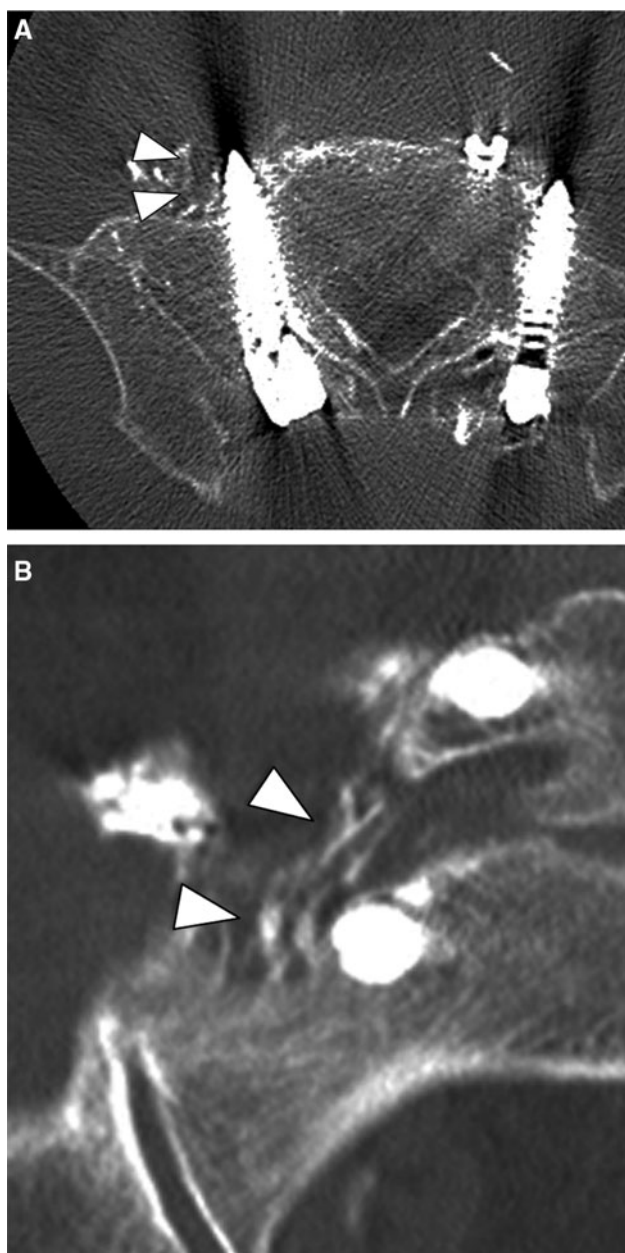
Computed tomography (CT) after the right L5 rootgraphy. a In the axial section, the right L5 nerve root is compressed laterally by the perforating S1 screw (white arrow heads). The right s1 pedicle screw passes diagonally against the pedicle medullary canal toward the far lateral side, at an outward angle of 15° and penetrates 9.0 mm distant from the anterior cortex of the sacrum. b In the coronal section, the L5 nerve root is compressed laterally by the perforating S1 screw (white arrow heads)
